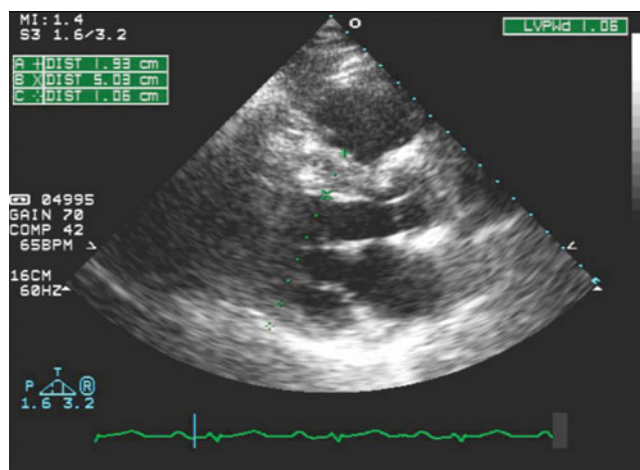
Case 5: TTE parasternal long axis view, 5 years follow-up, on medical therapy. Mild regression in septal hypertrophy (1.9 cm) compared to baseline measurements (see Fig. 24.17a)
